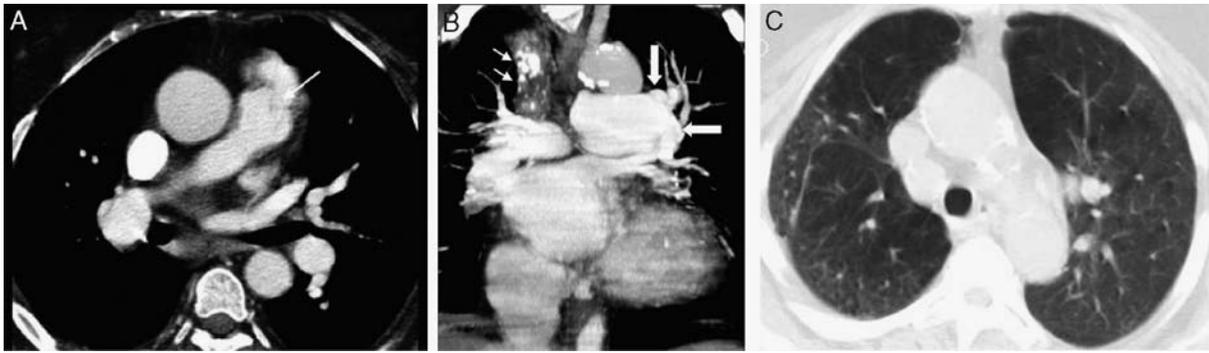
A 61-year-old woman after remote repair of tetralogy of Fallot. A, Contrast-enhanced chest CT shows postrepair distortion of the pulmonary valve (arrow). B, Coronal reconstructed images from a contrast-enhanced CT shows a thrombosed, partially calcified, right-sided Blalock-Taussig shunt (arrows). The left pulmonary artery is aneurysmal (thick white arrows). C, Lung windows show mosaic attenuation with patchy and asymmetric pulmonary blood flow, more prominent on the left. The right lung is smaller than the left. CT indicates computed tomography.
